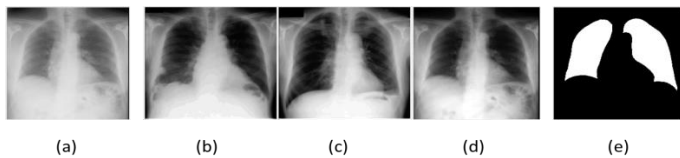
(A) Is The Patient Test X-Ray (B), (C), (D) are the Most Similar X-Ray to the Patient X-Ray in the Database Chosen According to the Shape Similarity Between The Lungs, (E) Averaged Patient Specific Lung Model
